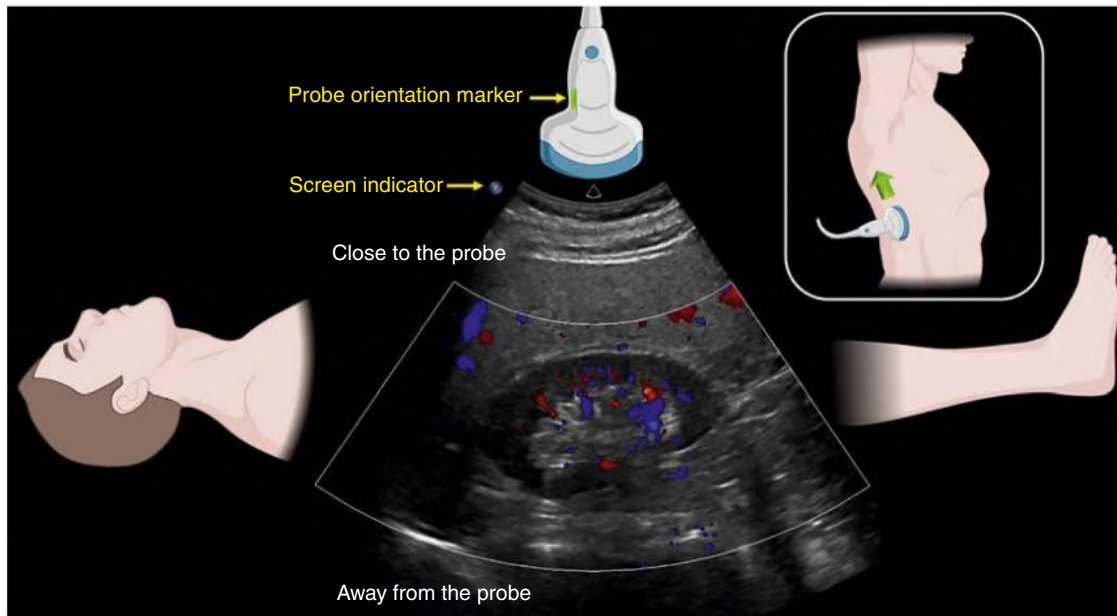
Orientation to an Ultrasound Image. The *green arrow* denotes direction of the probe orientation marker. The right kidney is shown here, but the principles remain the same for any organ being imaged. (Created with [Biorender.com](#).)
